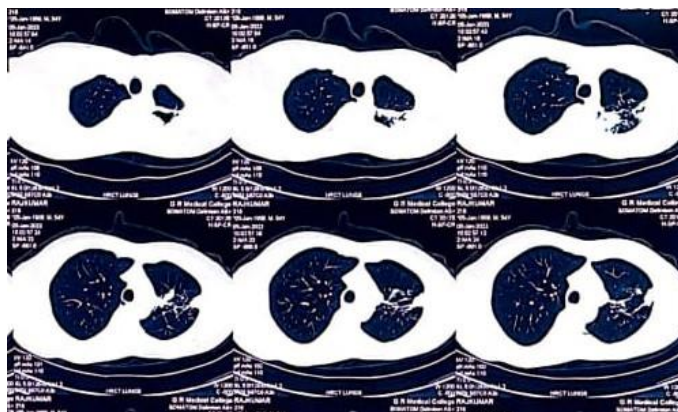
HRCT Chest shows collapse segment with cavitary changes
